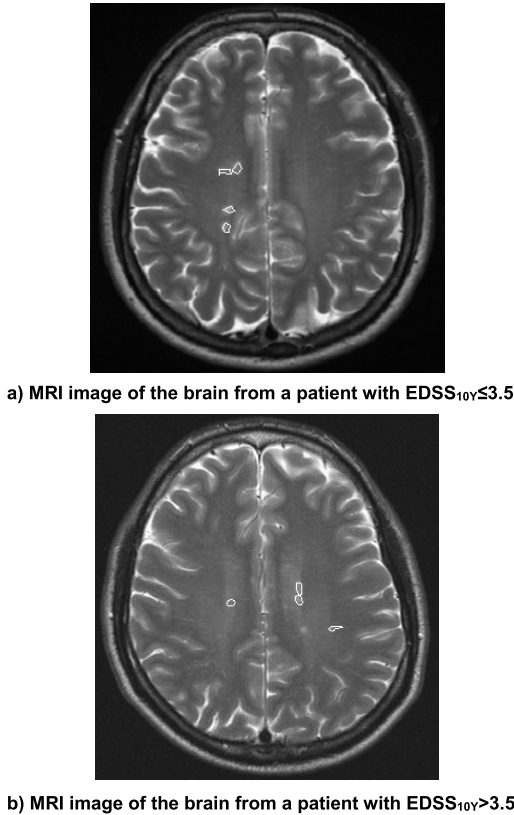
ROIs drawn on MR image of the brain at Time_{0Y}, obtained from: a) a 42-year-old female MS patient with an EDSS 2.0/2.5/3.0 and b) a 45-year-old male subject with an EDSS 2.5/4.5/7.5 (measured in Time_{2Y} /-, Time_{5Y} /- and Time_{10Y} /- after the initial examination). Segmented MS lesions are shown with outlines for both patients, acquired at a pixel resolution of 2.226 pixels per mm. The average gray scale median of all lesions was 91±12 and 140±14 (max=255) for the images in a) and b) respectively.
